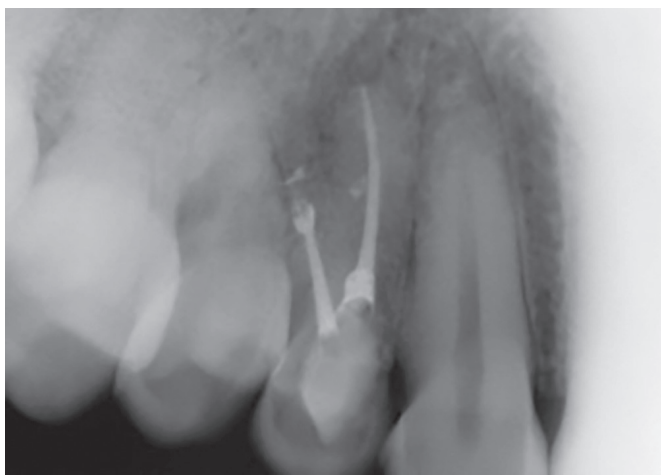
Final radiographic examination.
